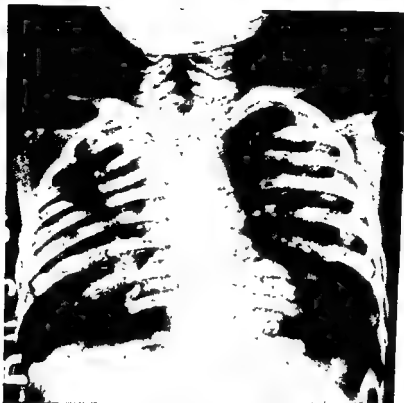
Antero-posterior roentgenogram of the spine of a 4 4/12 year old boy who entered the hospital complaining of wheezing and chronic bronchitis. Note spina bifida of the low cervical and upper thoracic spine with fusion of the bodies between T₁ and T₂. There is a large mid-line defect through the bodies anteriorly and a soft tissue mass extending into the right upper chest. This proved to be a neuro-enteric cyst containing intestinal epithelium connected by a narrow stalk about 5 mms. in diameter passing through the bony defect and attached to the ventral aspect of the spinal cord in the mid-line. Treated by division of the stalk and closure of the dural defect at laminectomy and removal of the cyst subsequently at thoracotomy.
